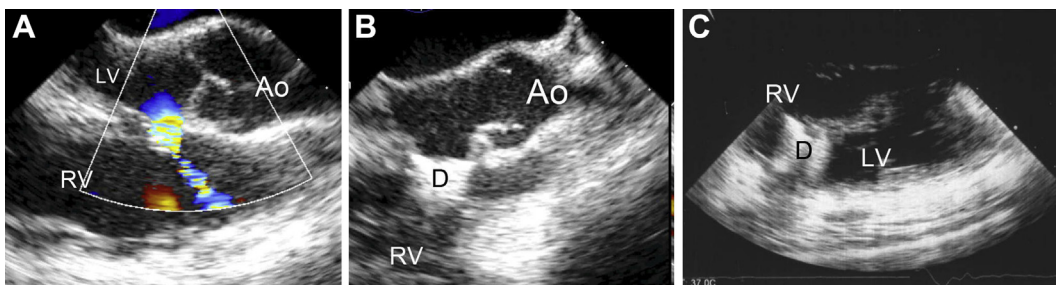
(A) Two-dimensional (2D) transesophageal echocardiography (TEE) and color Doppler images of membranous ventricular septal defect (VSD); (B) the Amplatzer PDA occluder was implanted on the membranous VSD; and (C) Amplatzer muscular occluder was deployed on the muscular VSD. Ao = aorta; D = Amplatzer occluder device; LV = left ventricle; RV = right ventricle.
